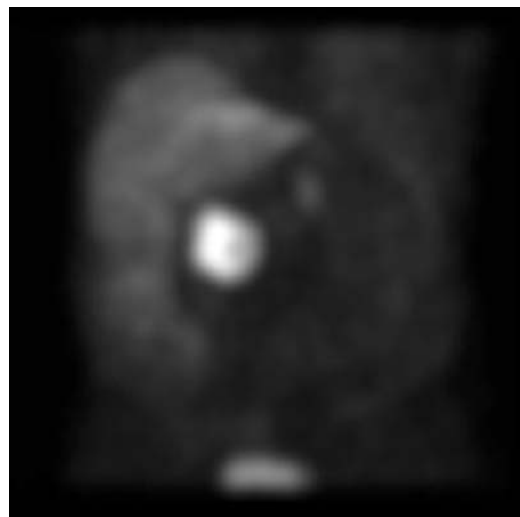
A metaiodobenzylguanidine scan with SPECT imaging, demonstrating a right peri-aortic paraganglioma.
